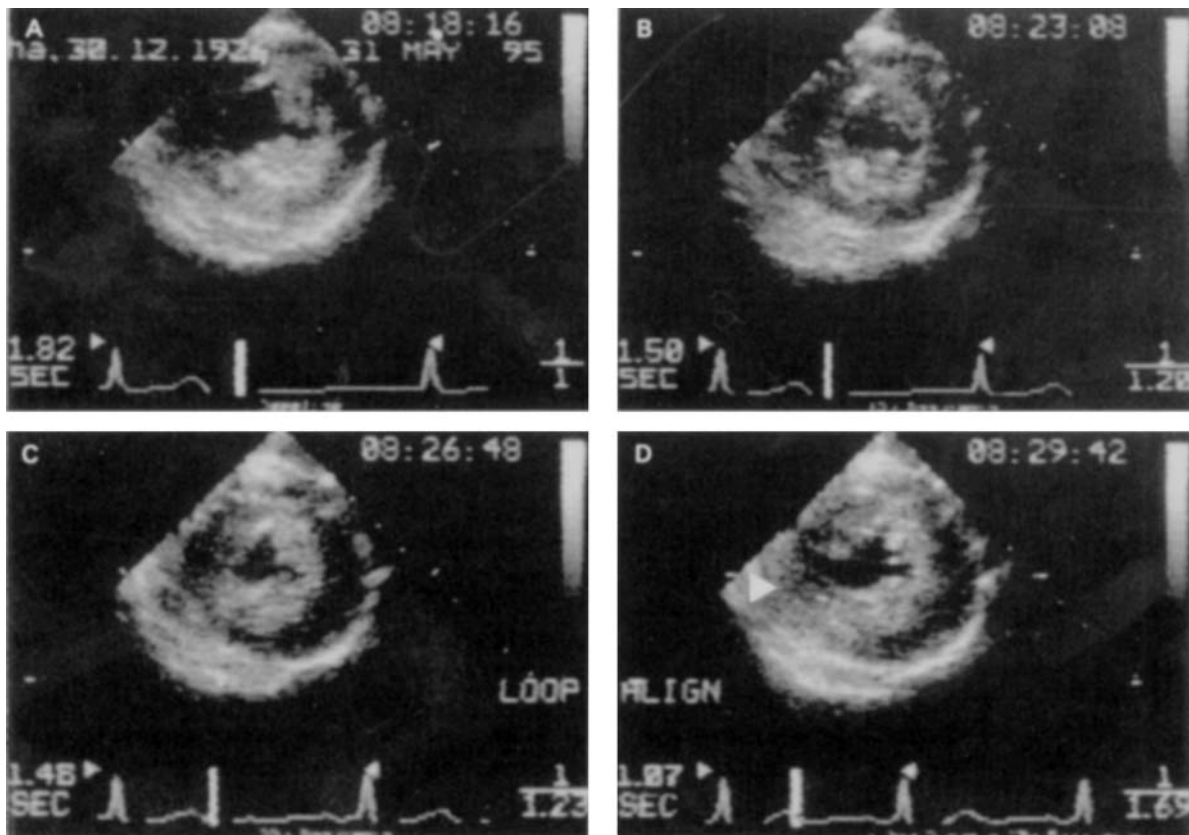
Segmental left ventricular contraction during dobutamine stress echocardiography in a patient anaesthetised with isoflurane-fentanyl.¹⁶ Echocardiographic images captured at end-systole in the mid-papillary short-axis cross-section show baseline segmental contraction during general anaesthesia (A), and contraction during gradually increased dobutamine infusion (3 minutes each) at (B) 10 µg/kg per min, (C) 20 µg/kg per min, and (D) 40 µg/kg per min. Segmental contraction improved or remained normal during dobutamine infusion in the inferior wall, the lateral wall, and the anterior wall. By contrast, induced myocardial ischaemia caused akinesia of the septum at 40 µg/kg per min (arrow).
